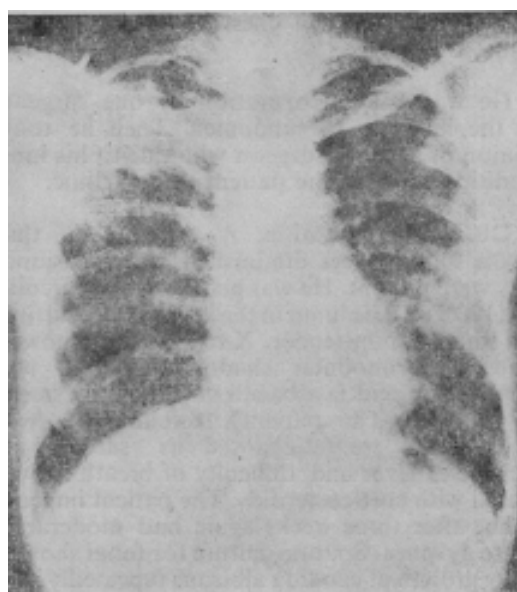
X-ray of chest shows bilateral pulmonary fibrosis.
